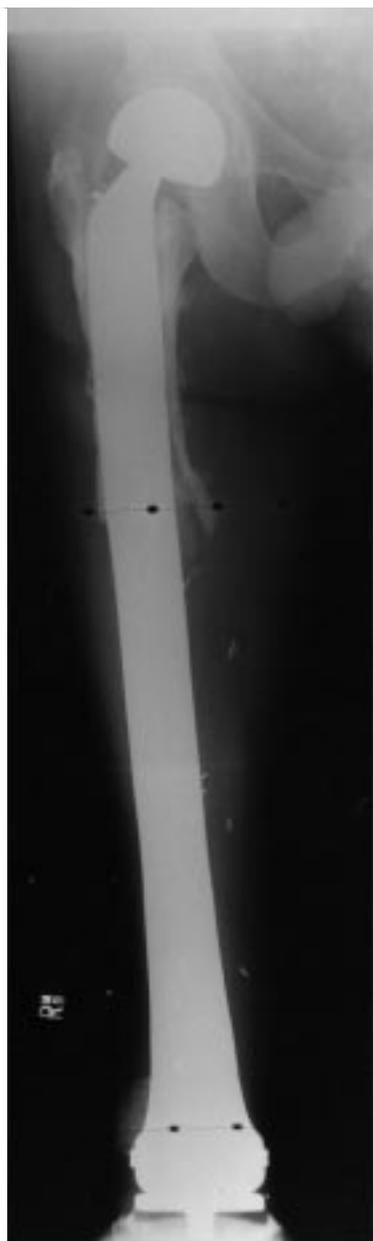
Radiograph of a large total femoral custom prosthesis with a bipolar hip component and a Kinematic rotating hinge prior to the use of the modular design (1988).
